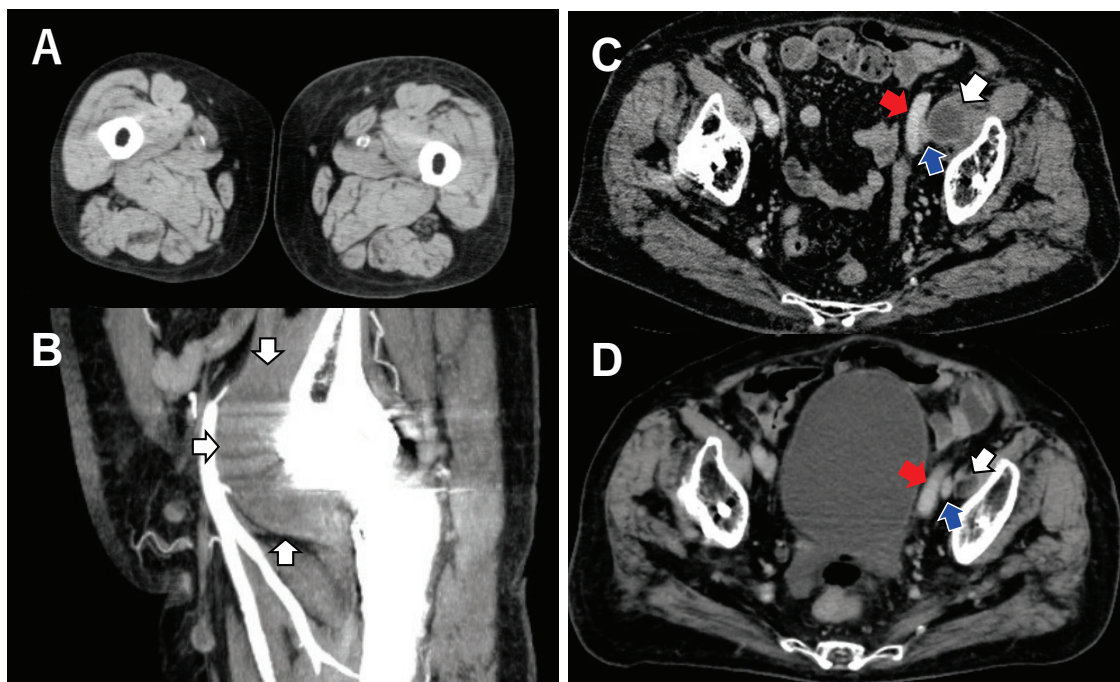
Contrast-enhanced computed tomography demonstrates left leg swelling without deep vein thrombosis (A) and a hematoma on the anterior surface of the replaced femur (B, C; white arrows). The hematoma and the left external iliac artery (C, D; red arrows) compress the iliac vein (C, D; blue arrows), causing leg edema.
